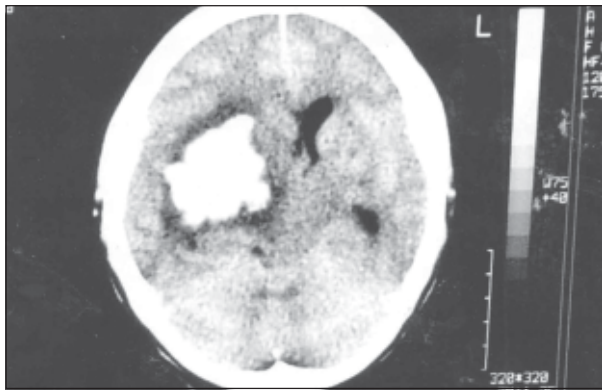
CT-Scan of brain showing large haematoma involving right capsuloganglionic area with massive perifocal oedema at right MCA territory with significant mass effect.
